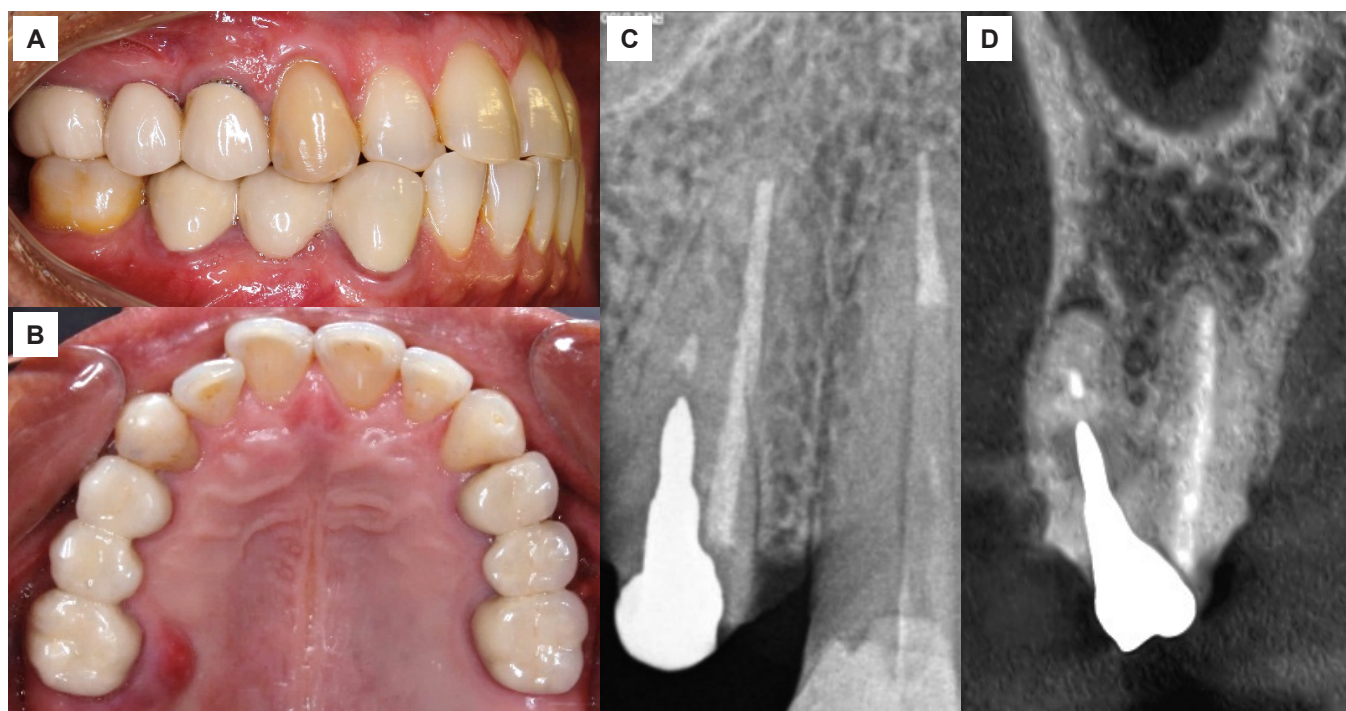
A) Initial occlusal photograph. (B) Initial maxillary occlusal photograph. (C) Initial mesio-angulated periapical radiograph. (D) Coronal tomographic section.
